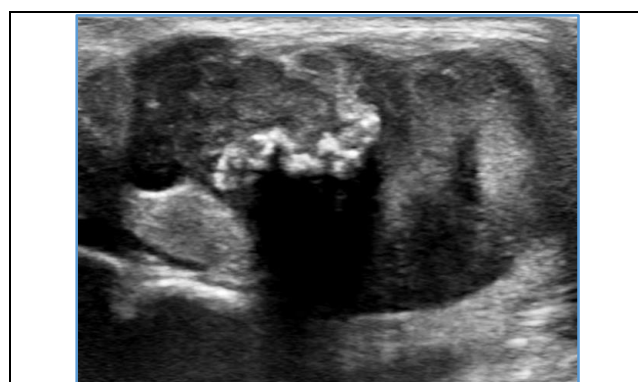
Pleomorphic Adenoma: Ultrasonography of Right Parotid Gland Shows Well-Defined, Lobulated, Hypoechoic Lesion with Coarse Calcification Within It
